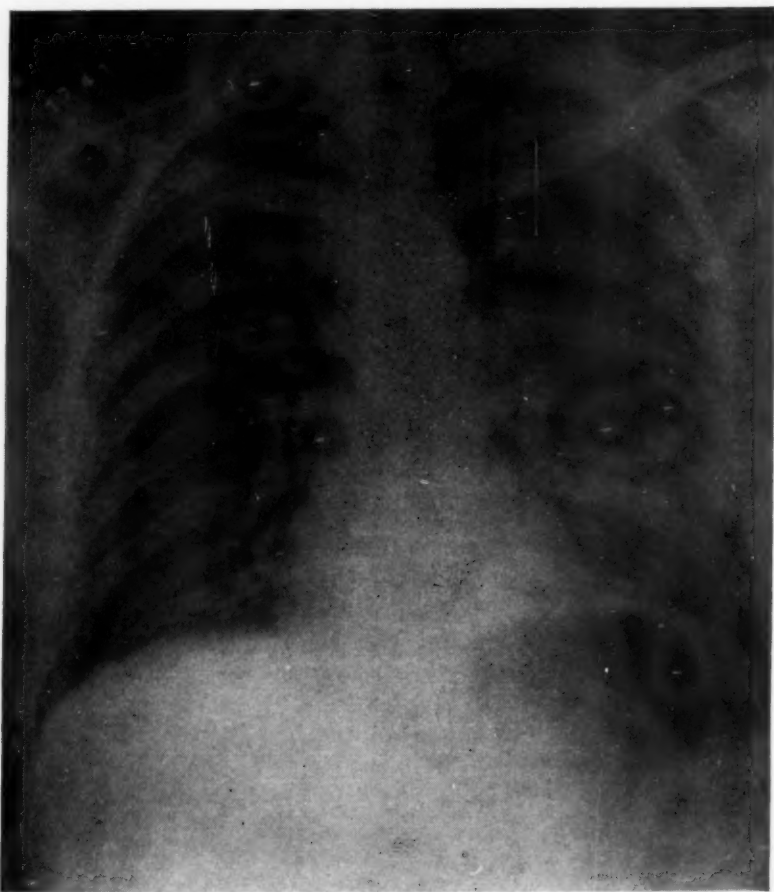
Roentgenogram of chest on the fourth day of illness, showing moderate involvement of the lower lobe of left lung.
